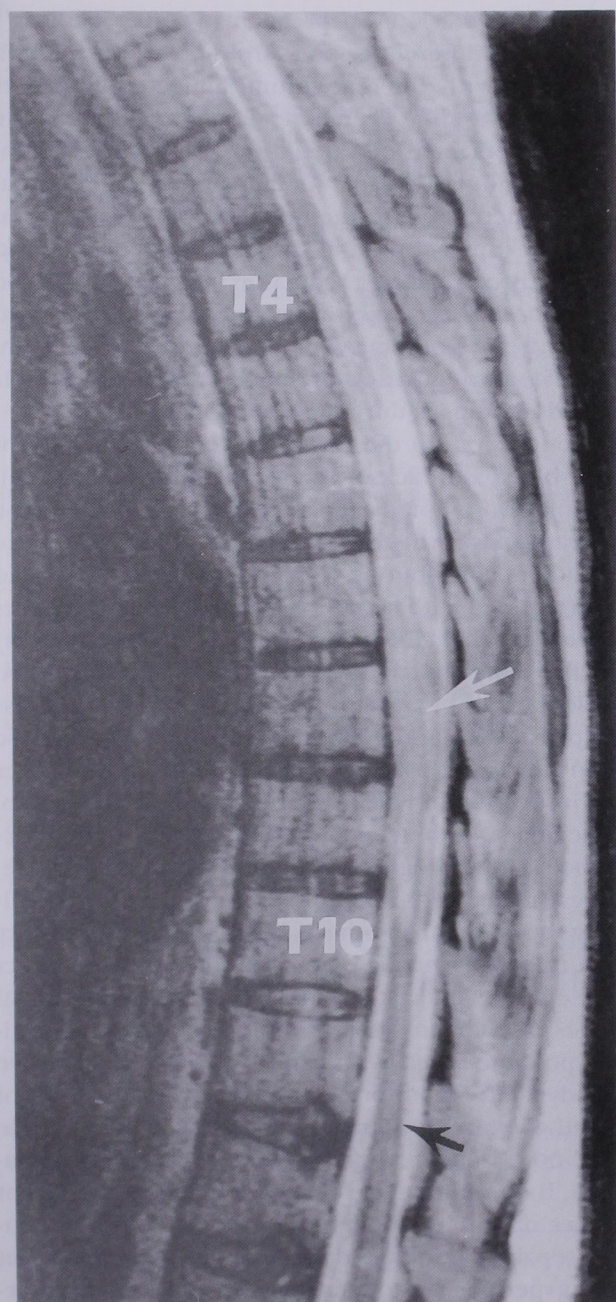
Twenty-four hours later, repeat MRI clearly shows development of abnormally high T-2 cord signal (white arrow) to the tenth thoracic level at which normal low cord signal is maintained (black arrow). Vertebral levels are represented by T4 and T10. The MRI finding is most indicative of spinal cord ischemic change.
